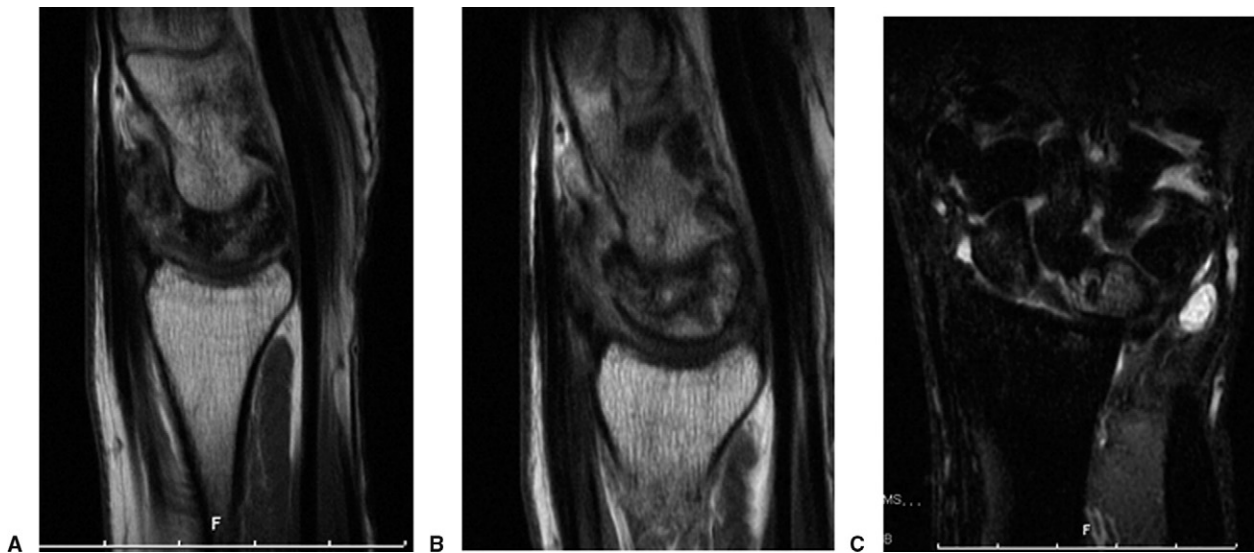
A, B Sagittal proton density and C coronal inversion recovery sequence MRI images through the lunate show a heterogeneous signal in the body of the lunate consistent with foreign-body reaction. There is also marked synovitis and effusion.
